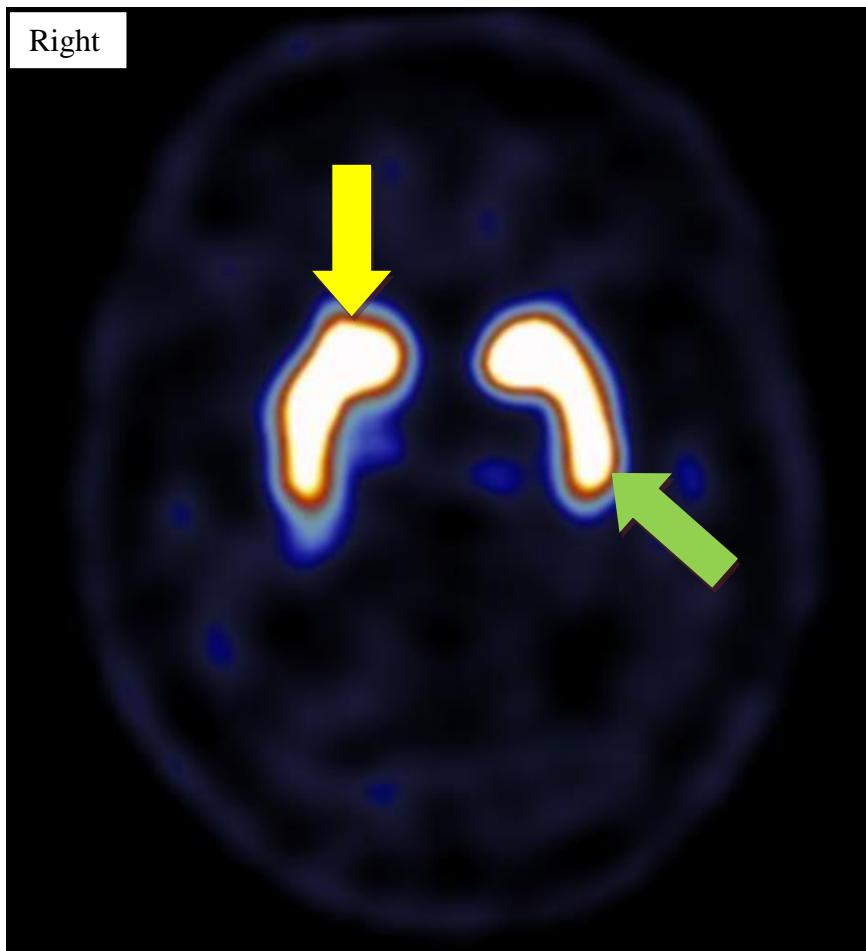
Image from normal FP-CIT SPECT scan demonstrating normal striatal uptake of the radioligand, in both putamen (green arrow) and caudate (yellow arrow).
